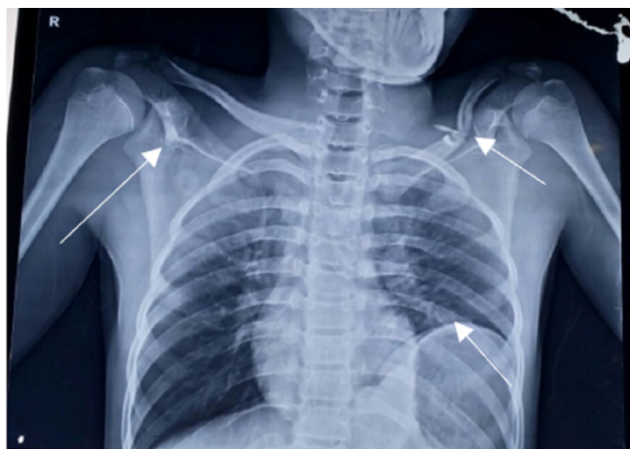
X-ray chest (Pre op); X-ray chest AP view showing bilateral clavicular fracture and right sided pulled up hemidiaphragm due to diaphragmatic rupture
